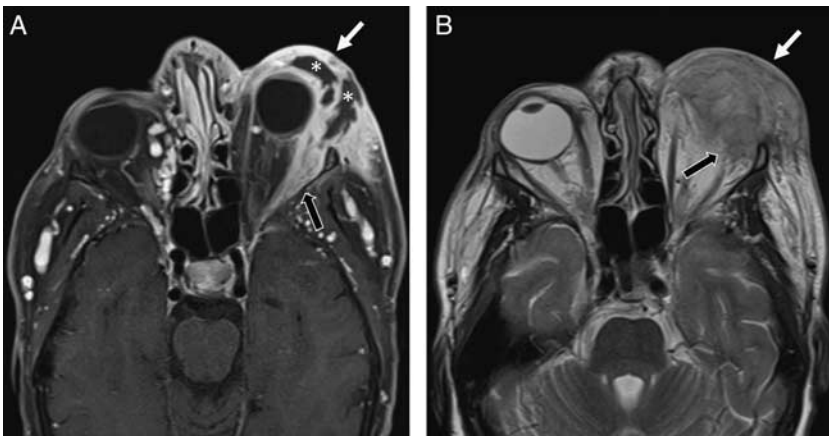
52-year-old woman presented to the emergency department with 2 weeks of left eye redness and swelling that was unresponsive to antibiotics. Axial T1-weighted postcontrast fat-saturated MRI (A) demonstrates thick, enhancing preseptal soft tissue (white arrow) extending posteriorly into the postseptal soft tissues (black arrow). There are areas of T1 hypointensity centrally, consistent with a multiloculated abscess (white asterisk). Axial T2-weighted MRI (B) demonstrates T2 hyperintense soft tissue thickening of the preseptal (white arrow) and postseptal (black arrow) soft tissues. MRI indicates magnetic resonance imaging.
